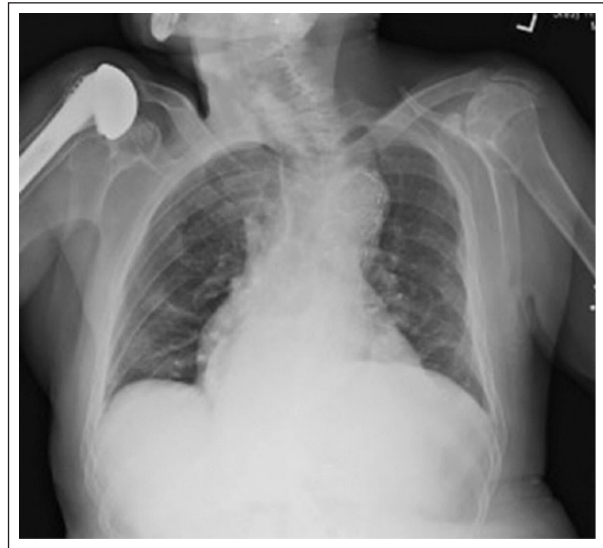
Post-deployment chest X-ray.
